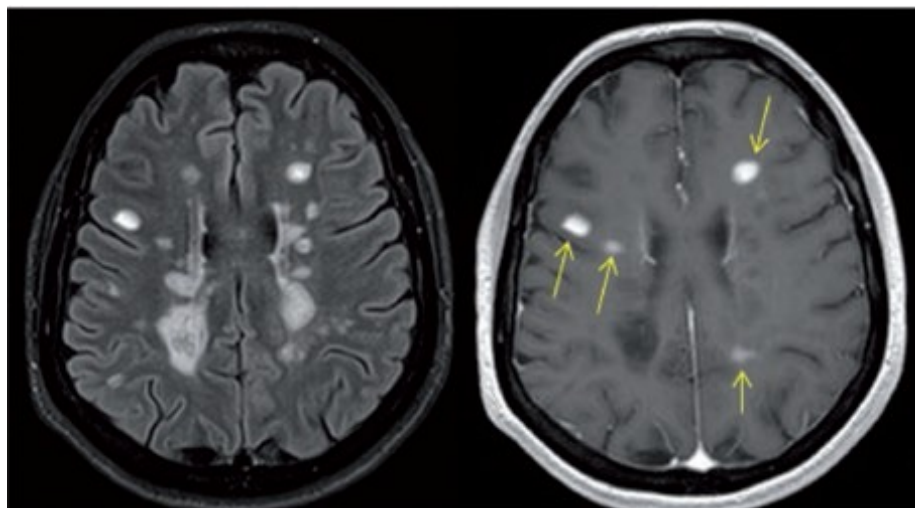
Conventional brain MR imaging in a patient with a diagnosis of MS. The flair-image (left) shows the typical multifocal demyelinating lesions involving the white matter of both brain hemispheres. The contrast-enhanced T1-weighted image (right) demonstrates those lesions with abnormal blood brain barrier permeability (arrows), a marker of inflammatory activity.(Tintore´ M et al2003
